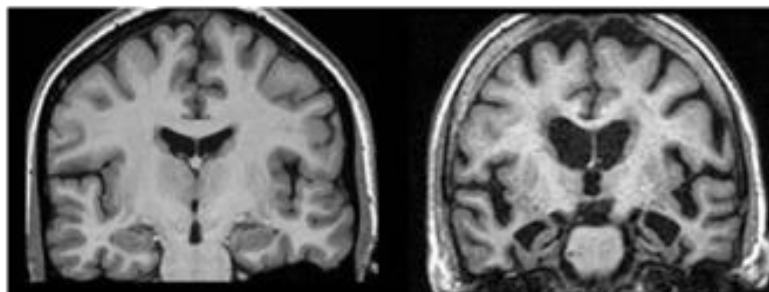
MRI brain images. Healthy (left) and AD (right)
